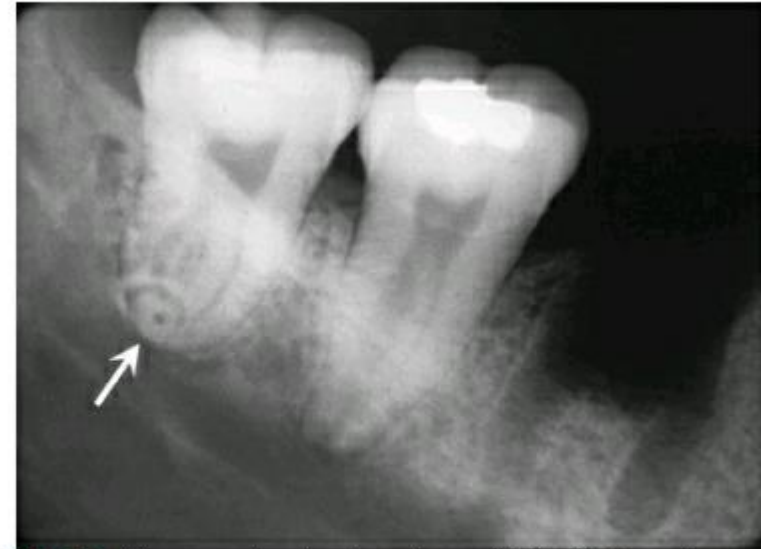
The most apical portion of this third molar root is dilacerated in the buccal-lingual direction so that its long axis lies along the path of the x-ray beam. Note the "bull's-eye" appearance of the root apex produced by the root canal, tooth root, and periodontal ligament space (*arrow*).
